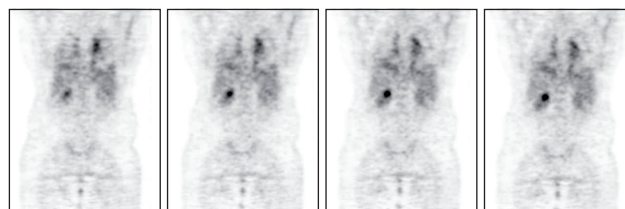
Images of <sup>18</sup>F-FDG-PET in a patient with FUO. These images demonstrate the underlying pathology, which turned out to be lung carcinoma, confirmed by surgical pathology.
